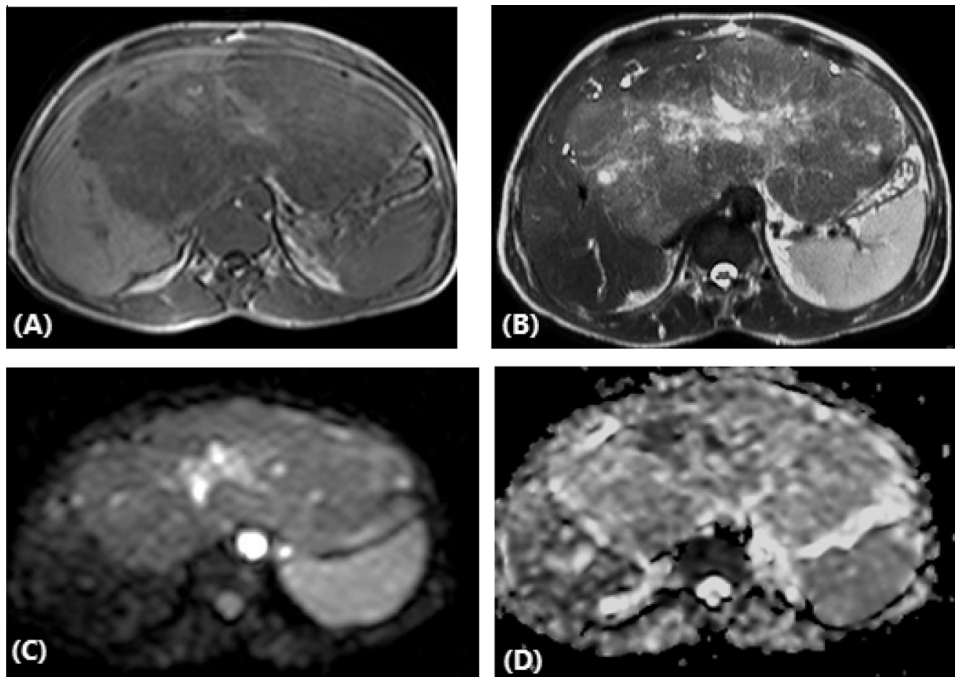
FNH in a 59 year-old female patient; (A) Axial T1-weighted image displays a well-defined large hypointense lesion within the left lobe. (B) Axial T2-weighted image discloses T2 iso/hyperintense lesion with central markedly hyperintense scar, consistent with focal nodular hyperplasia. (C) Axial single-shot echo-planar DW image ($b = 600$), the FNH is moderately hyperintense with more hyperintense central scar (D) On the ADC map, the lesion is isointense with a relatively low ADC value ($1.4 \times 10^{-3} \text{mm}^2/\text{s}$).
